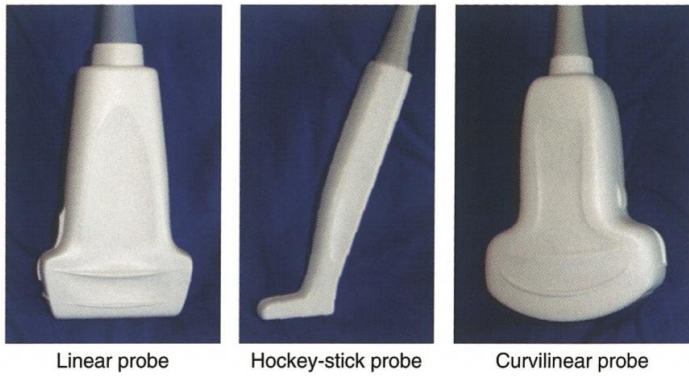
The common types of ultrasound probes
